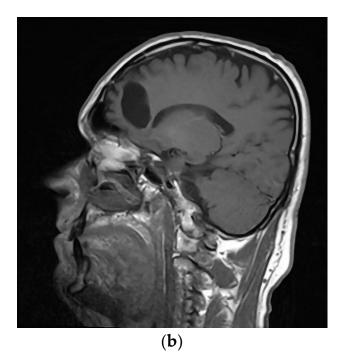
Postoperative MRI; (a) axial T2 slice; (b) sagittal T2 slice.
